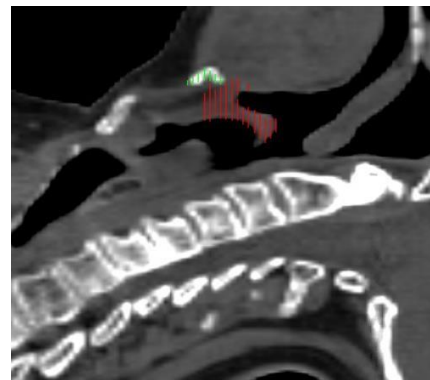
Patient A: Re-scan CT.
